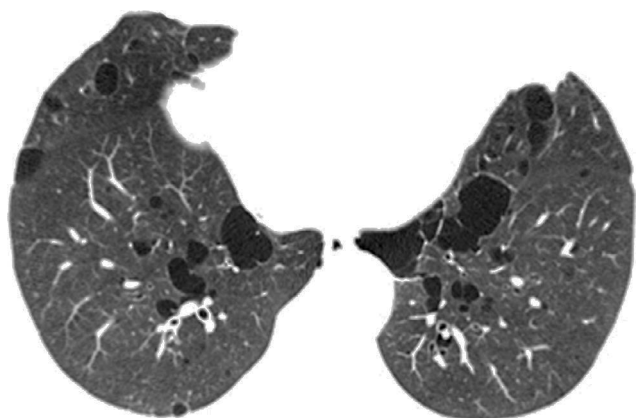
High resolution computed tomography of the thorax, axial scan at the level of the lower lobes (A) showing right pneumothorax, in addition to several cysts in the pulmonary parenchyma. Videothoracoscopy (B) evidenced the presence of subpleural cysts.
